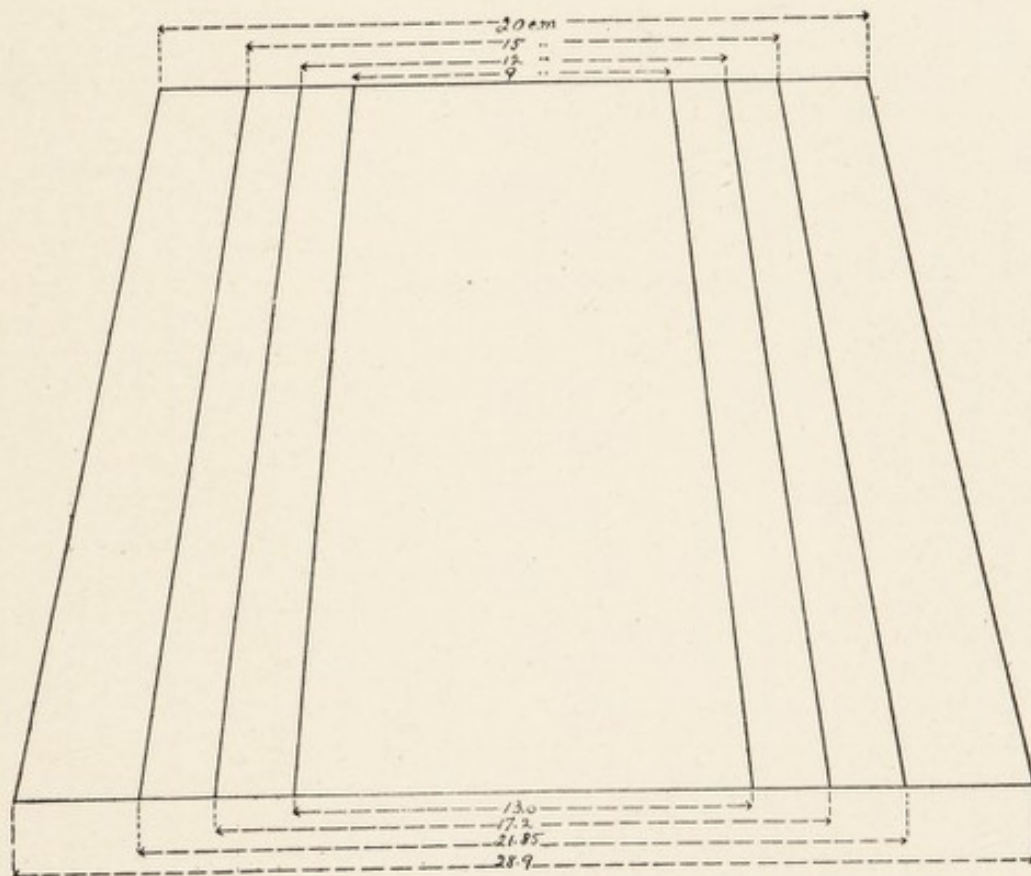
PATTERNS OF X-RAY BEAMS WITH VARYING PORTS OF ENTRY AND A F.S.D. OF 50 CM.
